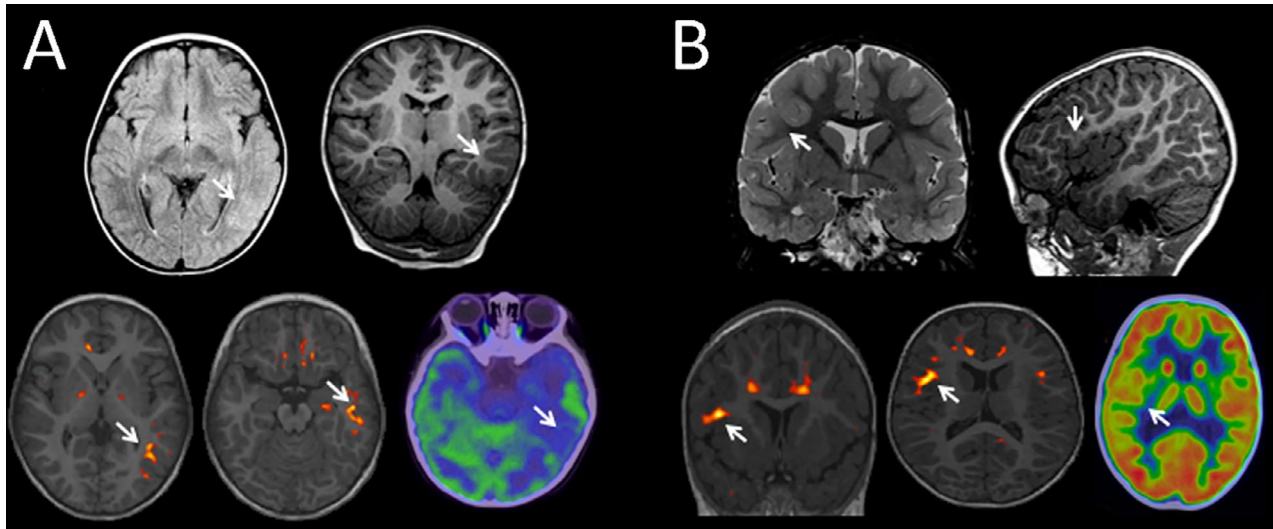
MRI and MAP images in two patients with focal epilepsy, younger than 36 months. Patient A: Top row shows axial FLAIR coronal T1 images interpreted as normal although retrospectively there is abnormal subtle high signal in FLAIR and hypointensity of the subcortical white matter in T1 (arrows). The bottom row shows MAP postprocessing demonstrating subcortical highlighted areas in the junction map and an asymmetric lesion (arrows) in the temporo-occipital parenchyma corresponding to the abnormal finding on FLAIR. PET-CT shows expected hypometabolism in the same area. Patient B: Top row shows coronal T2 sagittal T1 images interpreted as normal although retrospectively there is abnormal subtle high signal in T2 and hypointensity of the subcortical white matter in T1 (arrows). Bottom shows the junction map of MAP demonstrating an asymmetry (arrow) in the right frontal lobe. PET-CT shows hypometabolism in a more extensive area
